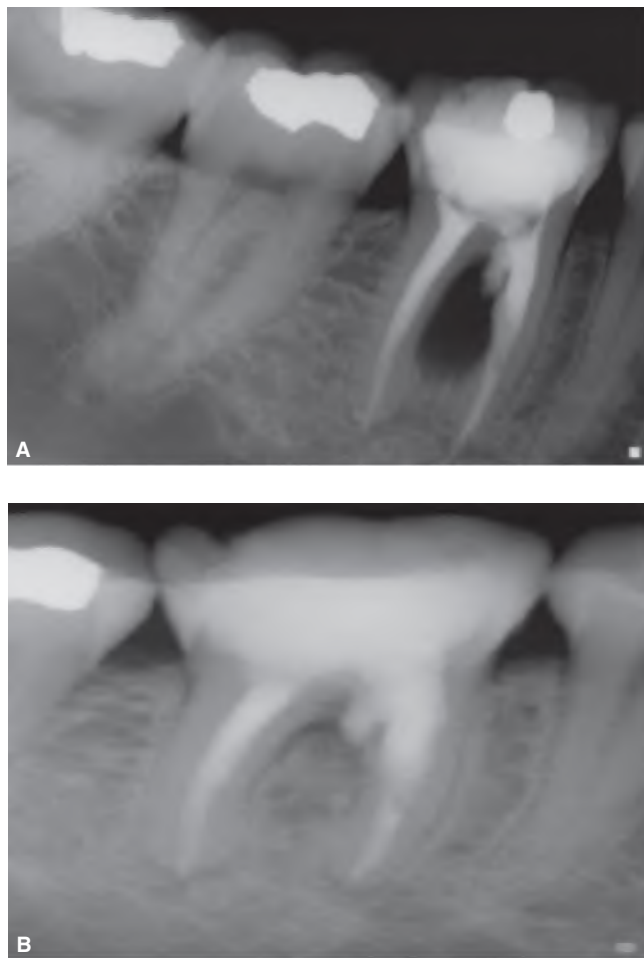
A. A strip perforation that occurred during cleaning and shaping was repaired internally with MTA. B. Radiograph taken 9 months later shows no evidence of pathology in the repaired area. (Courtesy of Dr. Albert Goerig, Olympia, Washington, U.S.A.)
